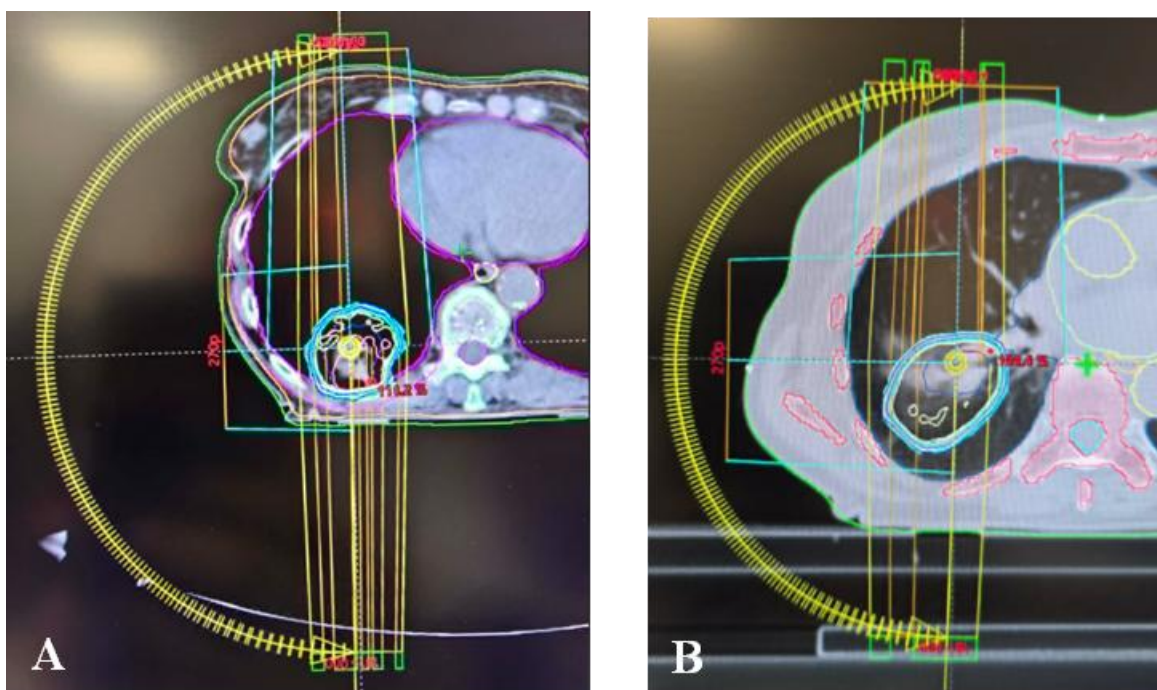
4D-CT-guided SBRT planning: A – Case I (standard CT window display), B – Case II (lung CT window display)
